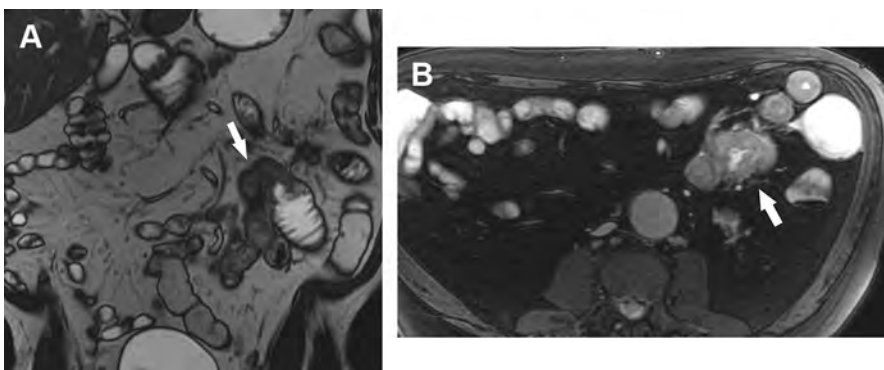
Jejunal adenocarcinoma. A 64-year-old man with melena. Coronal (A) and axial (B) T2-weighted images from magnetic resonance enterography show a focal mass (arrows) in the jejunum with mild proximal dilatation suggestive of an adenocarcinoma. Most sites prefer using CTE for evaluating occult bleeding; however, magnetic resonance enterography can be used if there are contraindications to CT.
